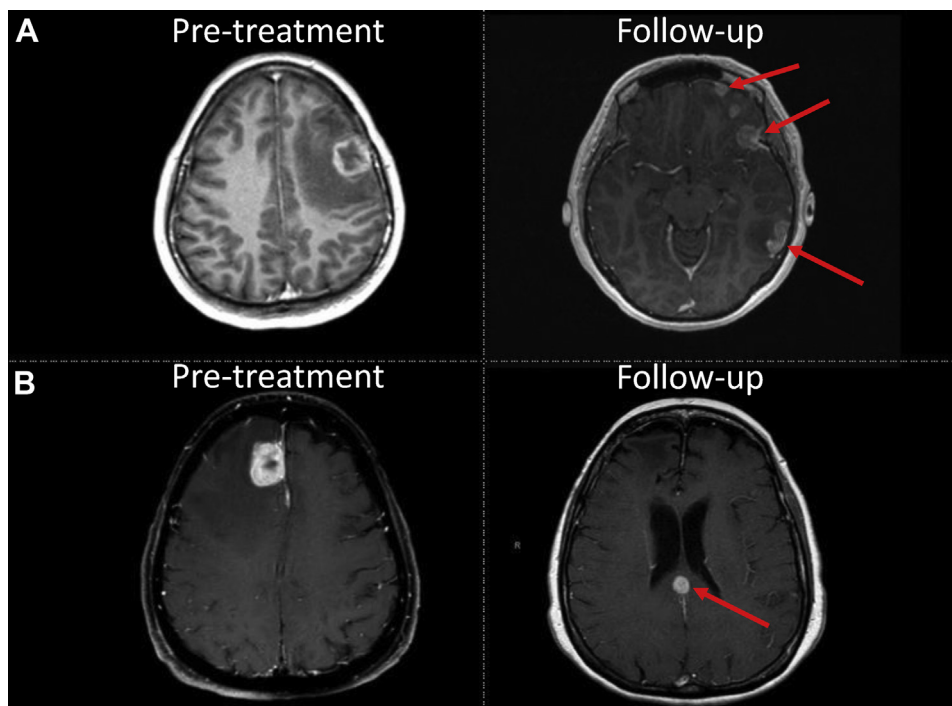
Pre-treatment and follow-up magnetic resonance images of patients with diffuse (A) or focal (B) leptomeningeal disease after their initial treatment.
